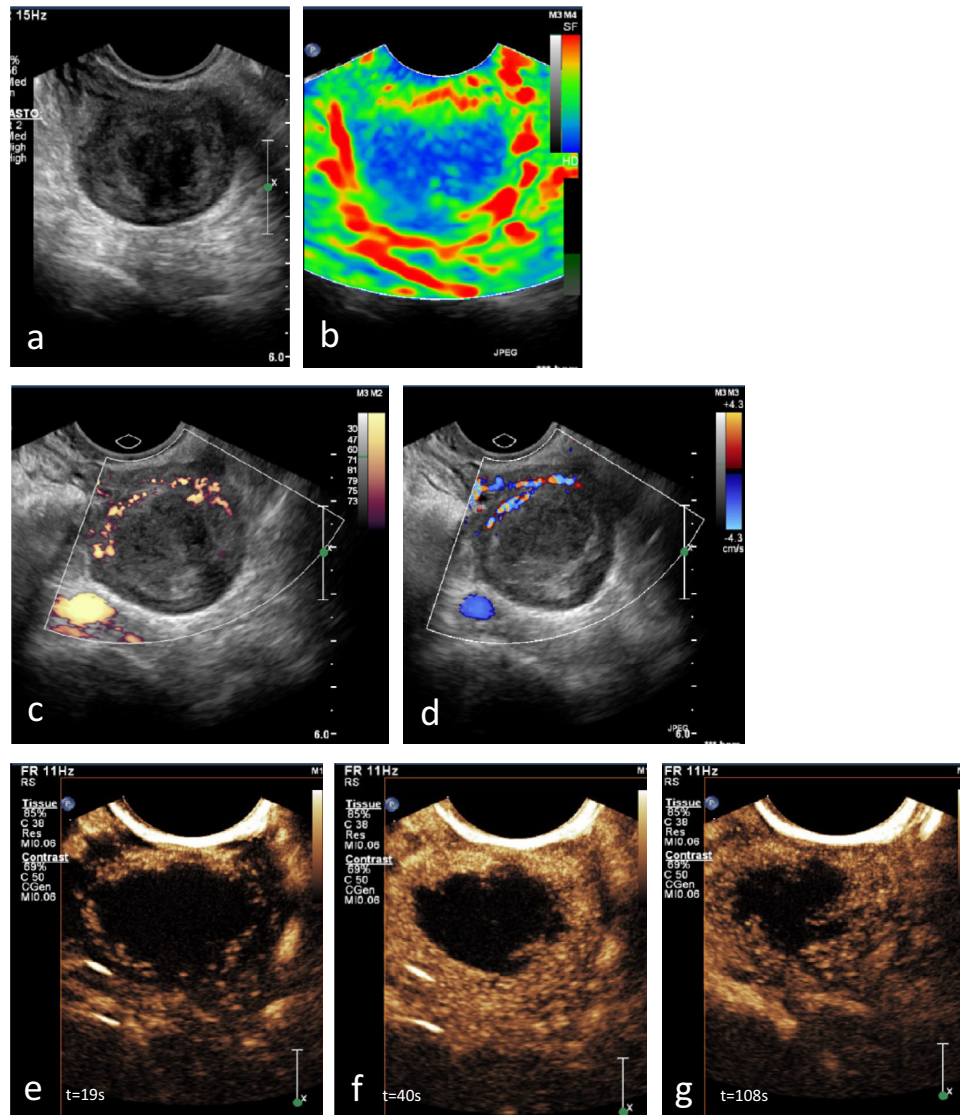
Subserosal fibroid (3.2 cm). All images were obtained from the third patient. (a) Gray-scale ultrasound revealing a well-delineated fibroid. (b) Sonoelastography image revealing the fibroid's center in *blue* (stiff tissue) with a pseudo-capsule in *red* (soft tissue). Small *green* areas indicate softer tissue present in the fibroid's center. (c) Power Doppler image revealing the pseudo-capsule. (d) Color Doppler image partially revealing the proximal site of the pseudo-capsule. (e) Contrast-enhanced ultrasound image at $t = 19$ s revealing initial enhancement of the pseudo-capsule. (f) Contrast-enhanced ultrasound image at $t = 40$ s revealing peripheral enhancement without enhancement in the center of the fibroid, that is, a large hypo-echogenic region. (g) Contrast-enhanced ultrasound image at $t = 108$ s revealing gradual wash-out of contrast from the fibroid.
